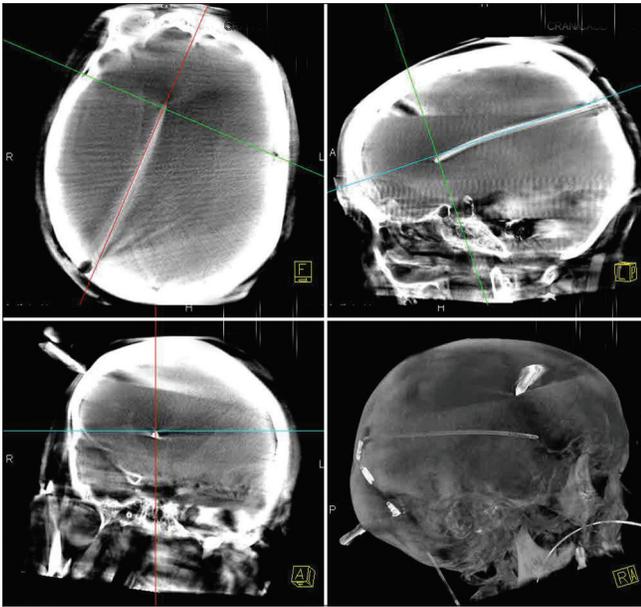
Reconstructed CB-CT images after the catheter insertion. These images allowing confirmation of ventricular catheter positioning. The catheter is inserted along the planned trajectory (red, blue, and green lines), and the tip reaches the target point
